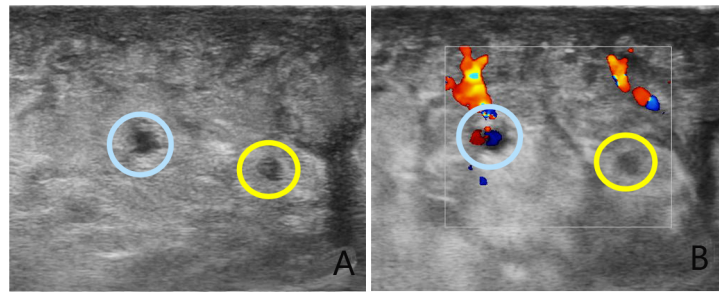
Lymphatic ultrasonogram. Of the D-CUPS (Doppler, Cross, Uncollapsible, Parallel, Superficial fascia) indices, D is explained. Blue circles indicate veins and yellow circles indicate lymph vessels. (A) B-mode image; (B) Doppler mode image. Vein is colored blue, but lymphatic vessel is not colored. (Link to YouTube video of lymphatic ultrasound: <https://www.youtube.com/watch?v=IYrxlgB9c-Q>).
